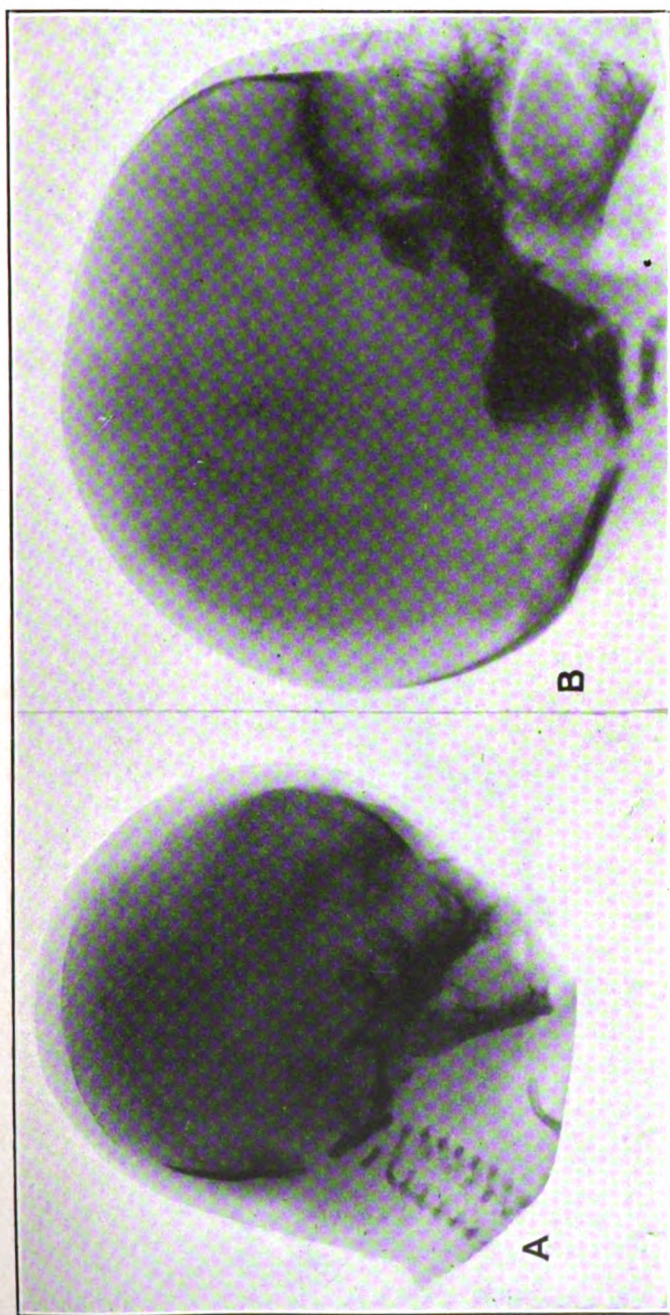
Roentgenograms of skull of fetus showing ossification centers at (a) seventeen to twenty weeks and (b) twenty-five to twenty-eight weeks, actual size.
